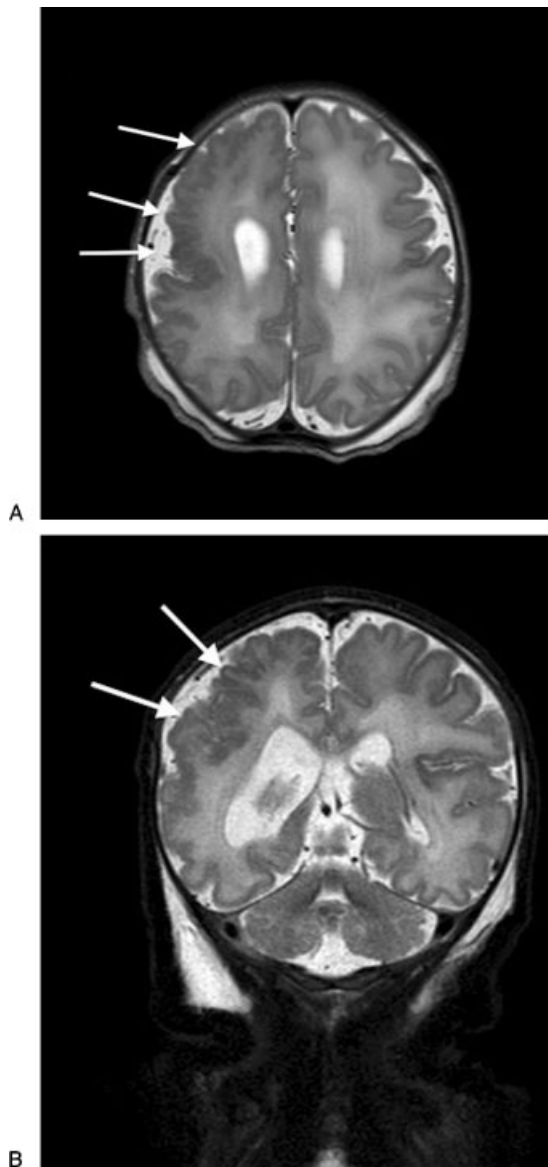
Patient brain magnetic resonance imaging (MRI). Axial (A) and coronal (B) T2-weighted postnatal MRI images of patient's brain demonstrating extensive polymicrogyria involving right frontal, temporal, and parietal lobes.
